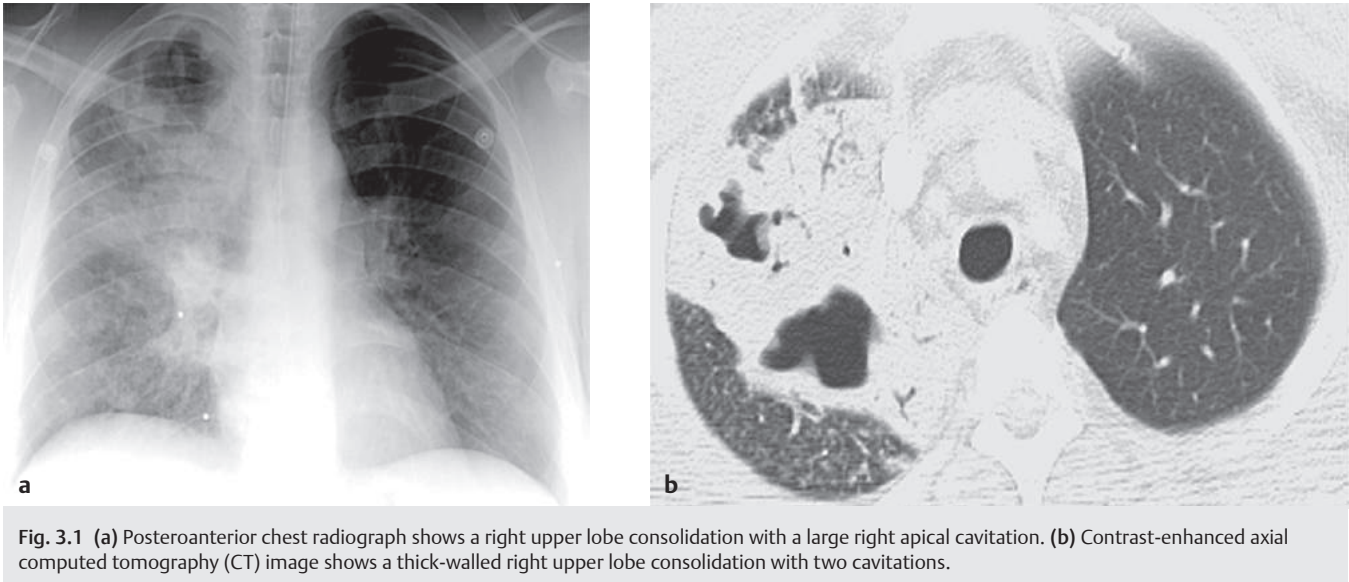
(a) Posteroanterior chest radiograph shows a right upper lobe consolidation with a large right apical cavitation. (b) Contrast-enhanced axial computed tomography (CT) image shows a thick-walled right upper lobe consolidation with two cavitations.
